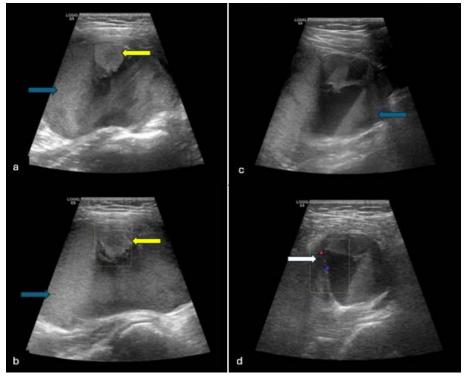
Ultrasound of the left gluteal soft tissue of a 10-year-old male patient revealed a large multiloculated soft tissue mass containing heterogeneous hyperechoic fluid-debris levels consistent with hemorrhagic fluid (blue arrow), measuring 10x6cm. Additionally, a nodule on the cyst wall showed no vascular signal on color Doppler, suggestive of a blood clot (yellow arrow). The mass was firm, without a change in shape upon probe compression. Peripheral vascular proliferation of the lesion was observed on color Doppler imaging (white arrow). The lesion was initially diagnosed as a hematoma on ultrasound.
